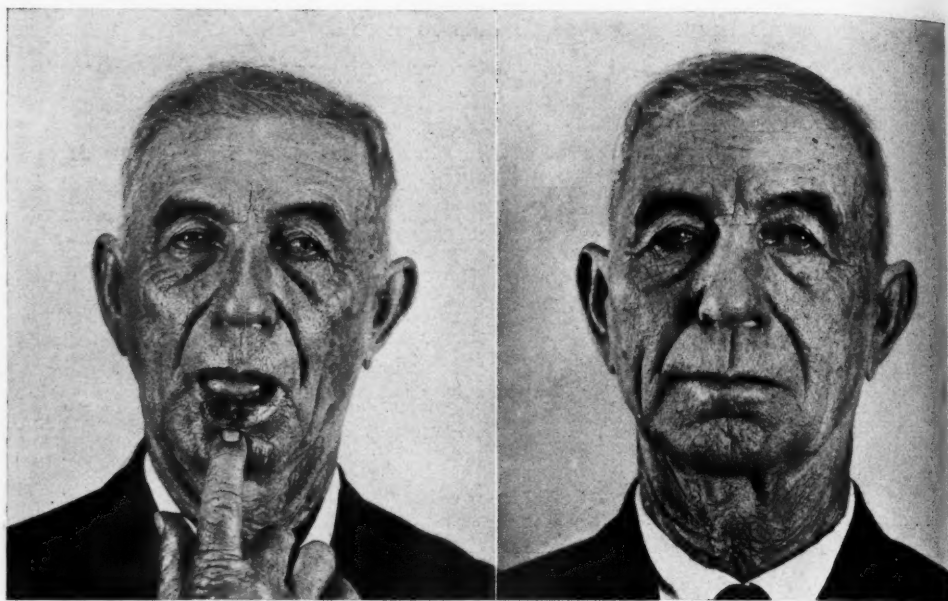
Farmer, age 65. Was first seen May 29, 1923. Family history was negative. Lower lip was injured in 1922. This was followed by formation of a hard lump and later by an ulcer. At time treatment was started, lesion covered half of lower lip (Fig. 9A, left). Clinical diagnosis was squamous cell carcinoma. Six double erythema doses of X-rays through a cone one inch in diameter removed every evidence of lesion (Fig. 9B, right). There had been no evidence of recurrence or metastases January 10, 1926.
